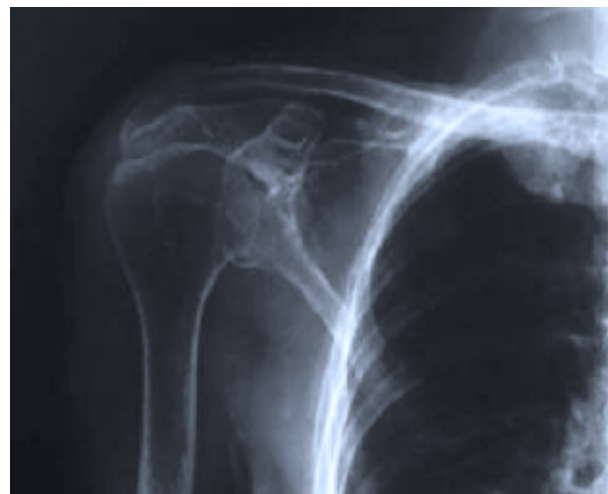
X-ray of shoulder joint
